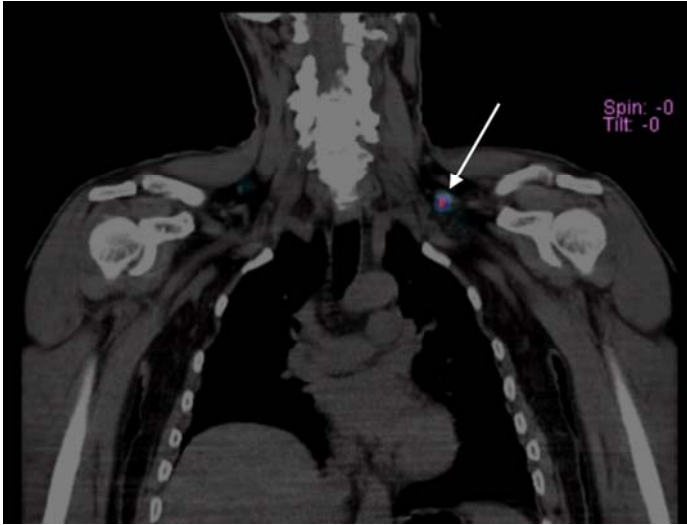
Nuclear medicine lymphoscintigraphy with a coronal view of the left posterior neck node highlighting the proximity to the course of the spinal accessory nerve. White arrow indicates location of node.
